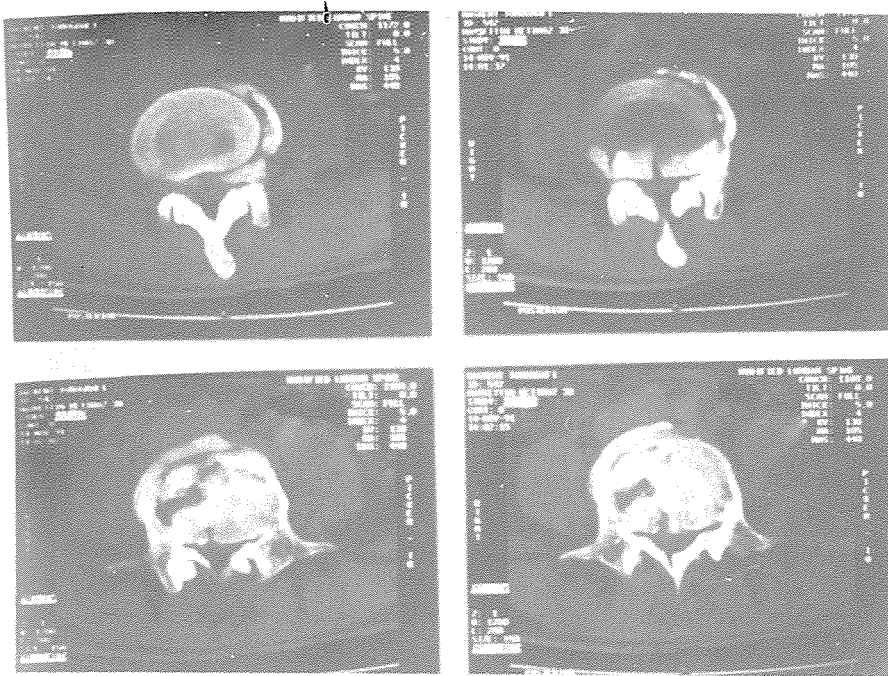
Preoperative CT of the same patient.
